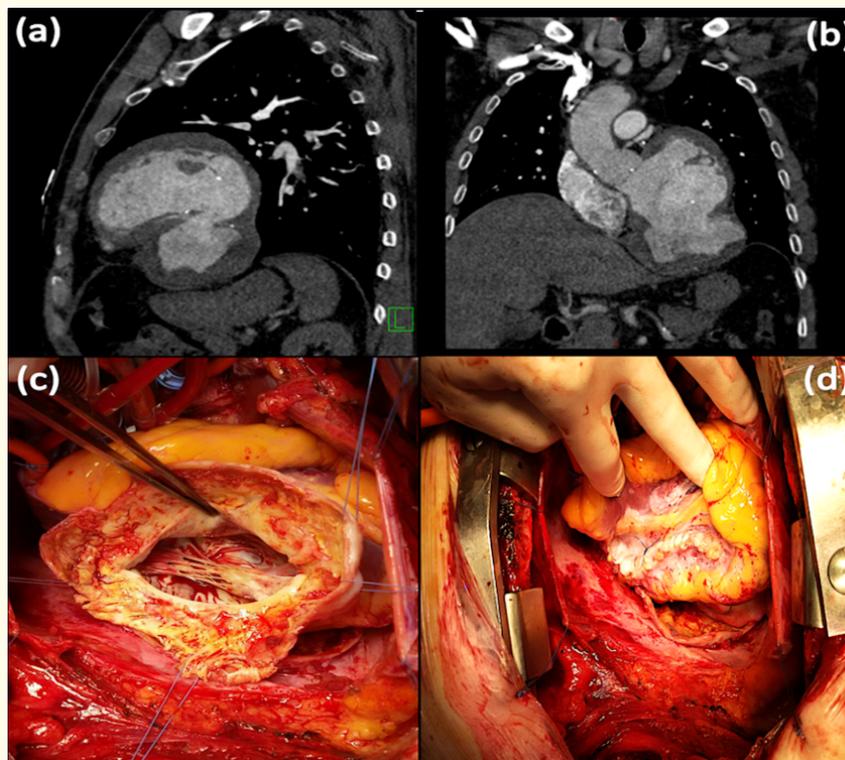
Multi-planar reconstructed computed tomography (A and B) showed a giant pseudoaneurysm of left ventricle (9.5 x 9.3 x 4.2cm). Intraoperative image showed an opened pseudoaneurysm sac (C) and the closure of wall defect using Dacron patch, covered with a single layer of 3/0 Prolene sutures using a piece of aneurysmal wall (D).
